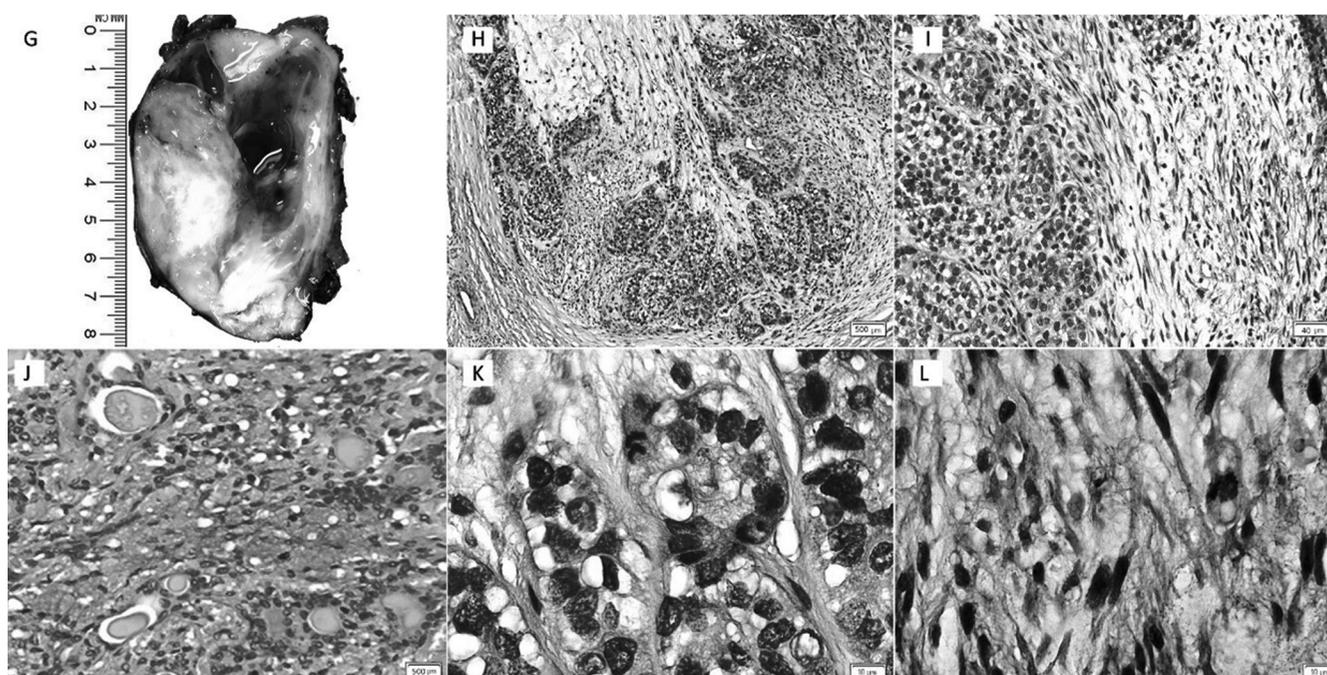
CT scan of the head and neck, parotid gland mass, and aspiration cytology
